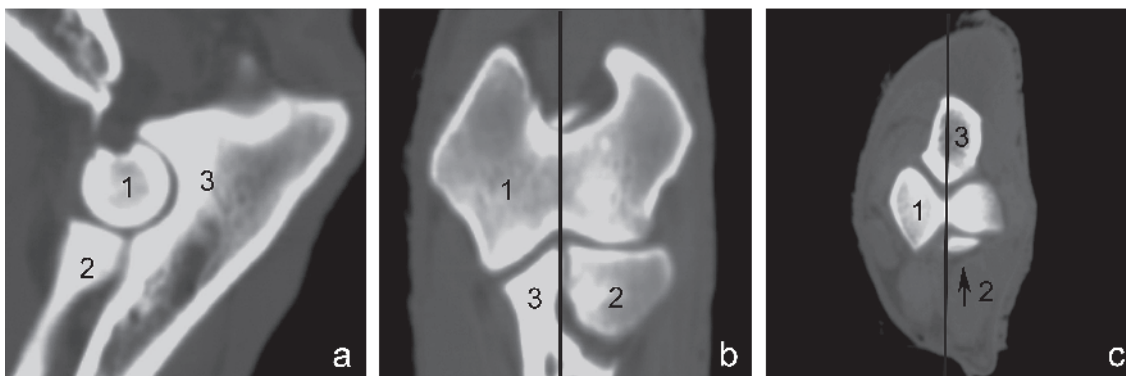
Computed tomography elbow slice and reconstructions. a) Sagittal; b) dorsal; and c) transverse views. The sagittal elbow plane used to study humero-ulnar congruity was selected using computer software to cross a line (black line) that passed in the humeral trochlea groove in the dorsal and transverse elbow planes. 1 = humerus; 2 = radius; 3 = ulna.
